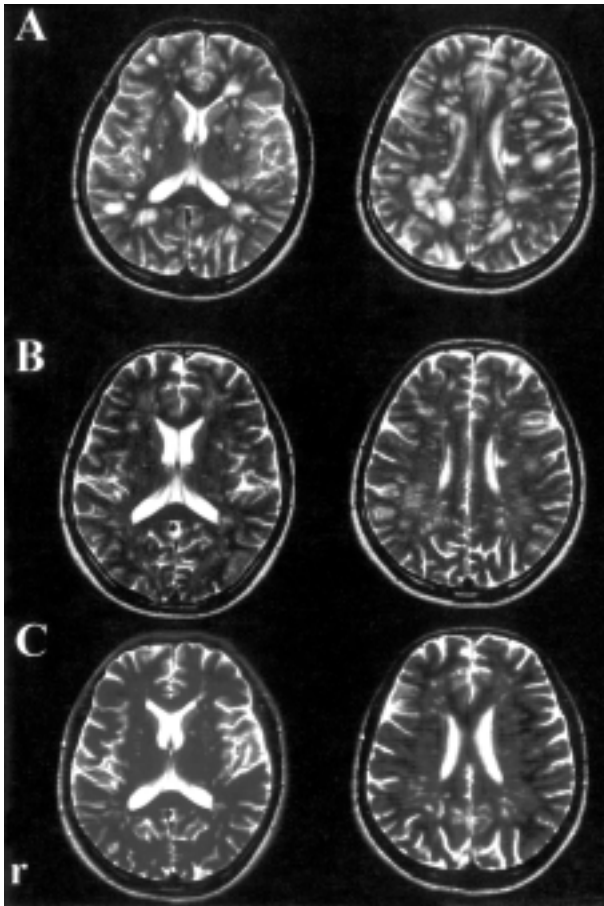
Serial brain MRI on T2WI in patient 2, with multifocal demyelinating leukoencephalopathy after levamisole therapy. (A) Initial brain MRI on March 29, 2004, showed multiple small high-signal intensity lesions in the subcortical white matter areas of the bilateral hemispheres and basal ganglia. (B) The repeated brain MRI on April 12 revealed a resolution of the high signal lesions. (C) The follow-up scans in April 27, disclosed a nearly complete recovery of the subcortical white matter and basal ganglion lesions.
